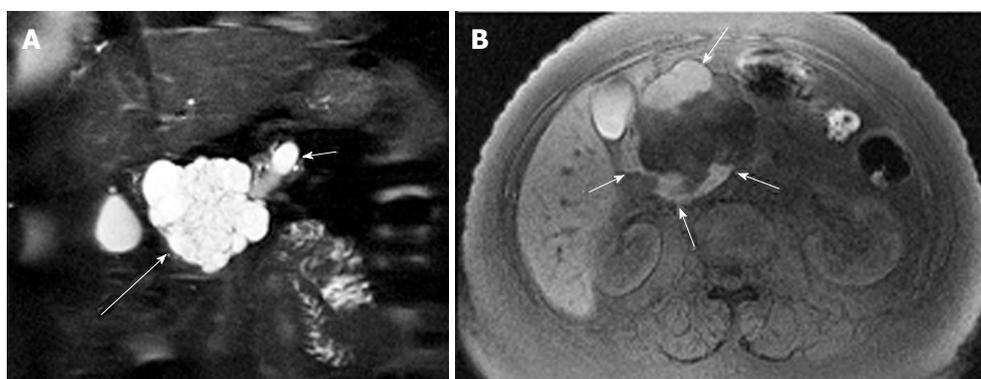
A 57-year-old female with mixed microcystic and macrocystic serous cystic neoplasm. A: Coronal T2-weighted single-shot fast spin-echo magnetic resonance (MR) image with fat saturation shows a cystic mass (large arrow) in the pancreatic head consisting of central microcysts and peripheral macrocysts. The small arrow indicates dilatation of the upstream main pancreatic duct. B: Axial T1-weighted gradient-echo MR image with fat saturation shows high intensity fluid in the macrocysts (arrows), representing hemorrhage. Hemorrhage may be seen in macrocysts, although it is uncommon.
